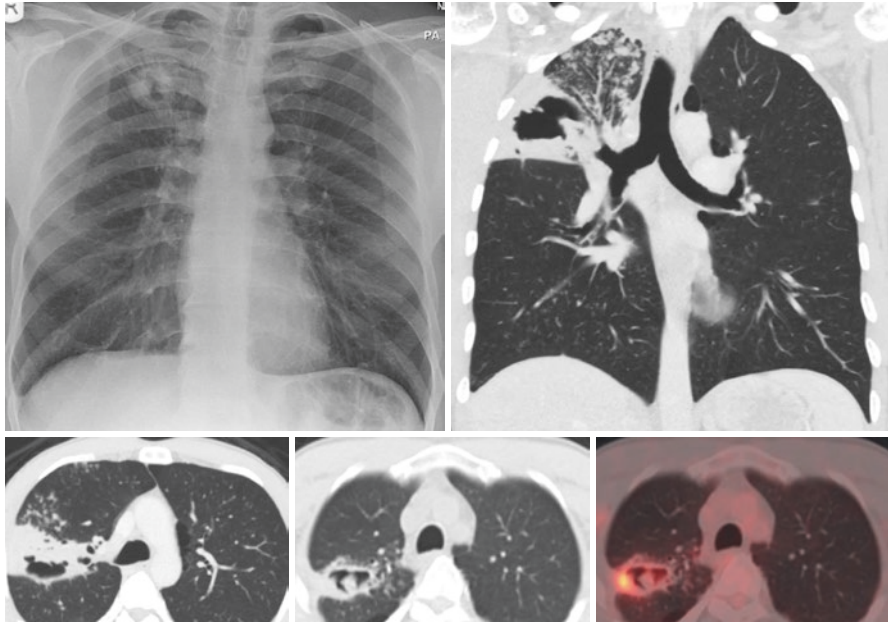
CXR and CT showing right upper lobe cavity and evolution of aspergilloma over 18 month. FDT-PET showing avidity in cavity
